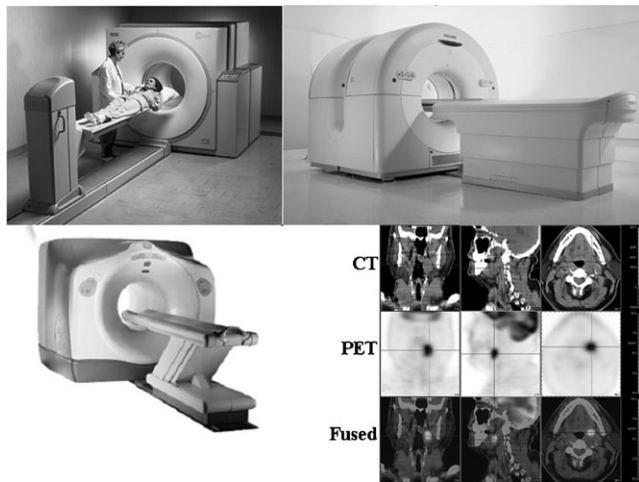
Commercial PET CT systems. These systems combine a fully functional CT scanner with a PET tomograph. The devices shown are the Siemens Biograph, Philips Gemini, and GE Discovery. The lower right image shows an example of the fused PET ^{18}F FDG and CT image data of a patient with lingual tonsillar carcinoma.
